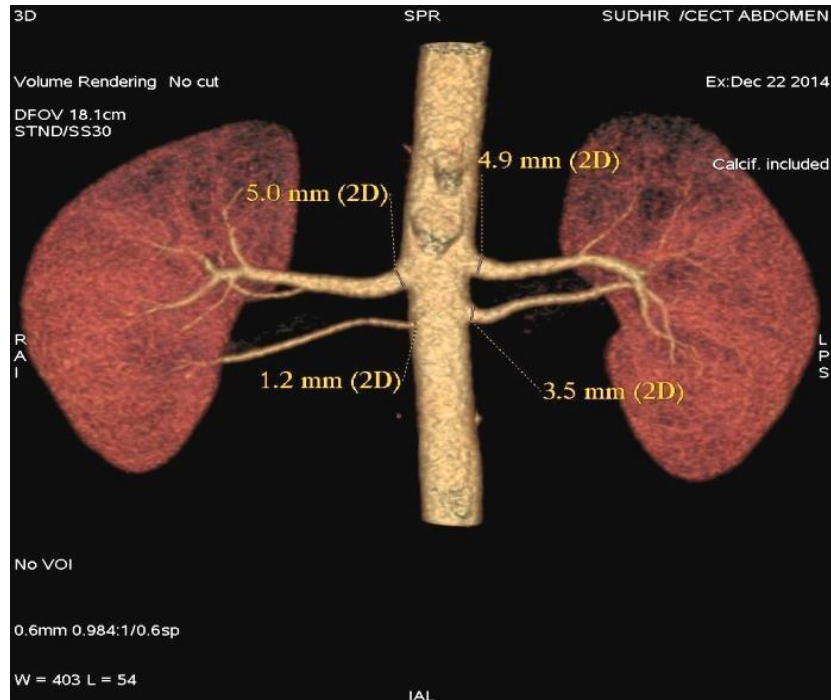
3D CT angiographic image showing measurement of diameter of right, Left renal arteries, and accessory renal arteries at origin from abdominal aorta
